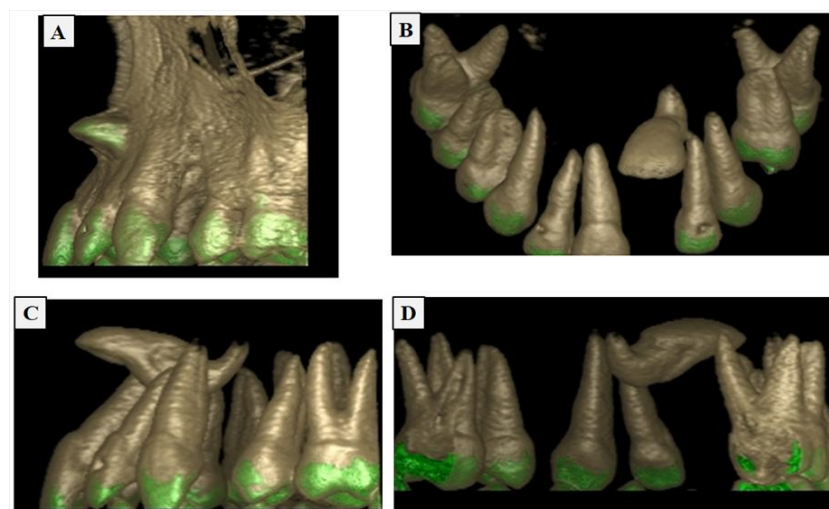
A-D: Three-dimensional CBCT visualization of severe trauma-induced dilaceration with root deformation and impaction in the maxillary anterior region.
